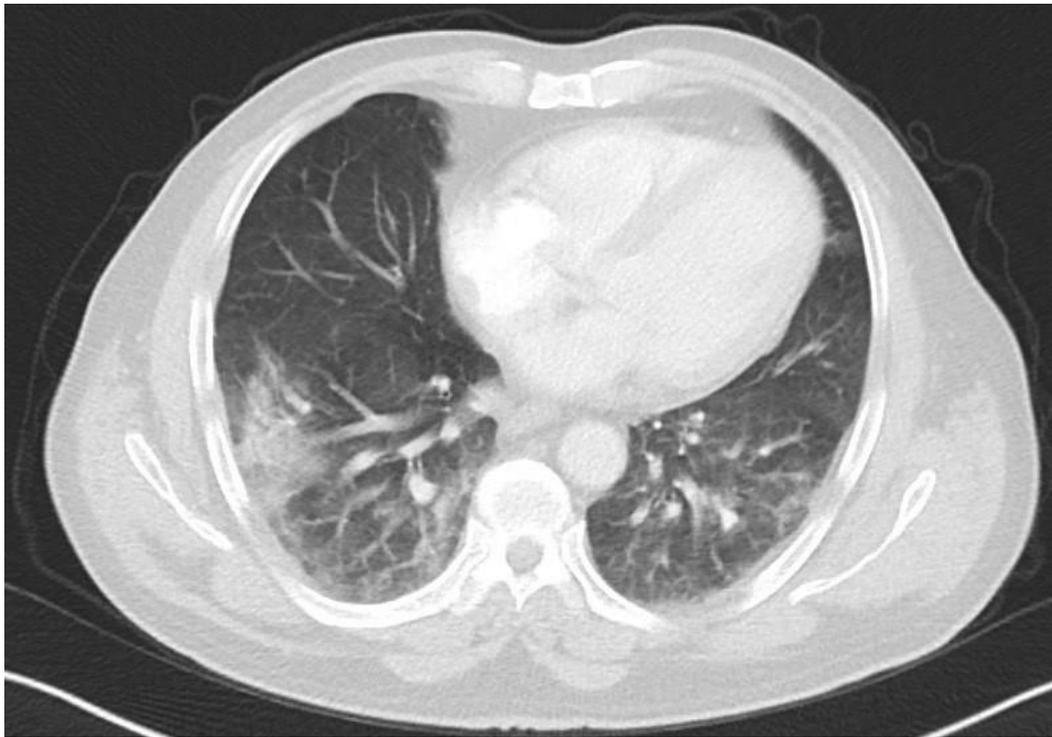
Chest computed tomography shows patchy peripheral ground glass opacities in both lungs, findings compatible with moderate Covid-19 pneumonia.
